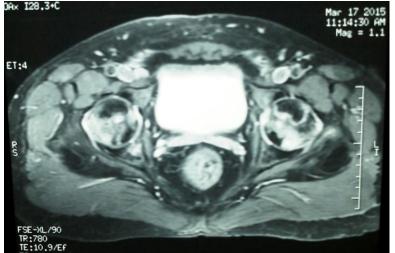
T2 weighted MRI scan of the pelvis.
